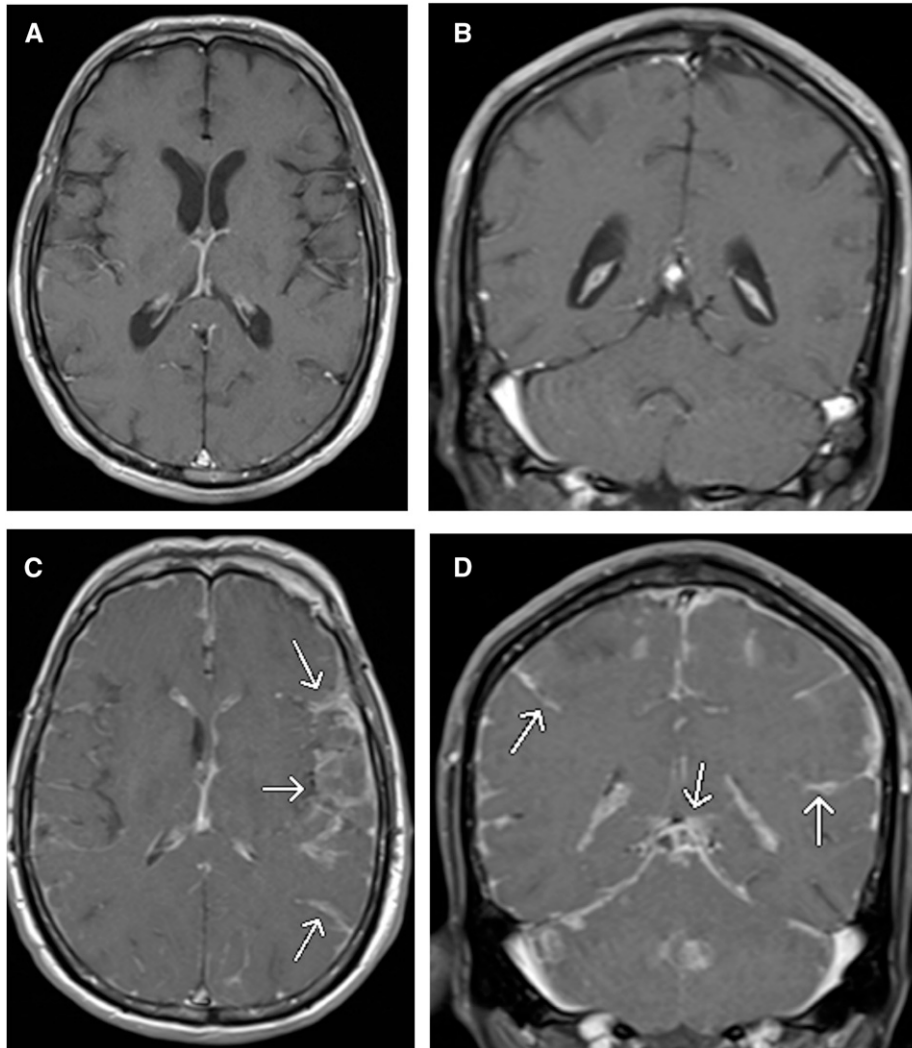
Initial axial (A) and coronal (B) contrast-enhanced T1-weighted MRI images show no abnormal enhancement. Subsequent axial (C) and coronal (D) contrast-enhanced T1-weighted MRI images show new diffuse leptomeningeal enhancement (arrows).
